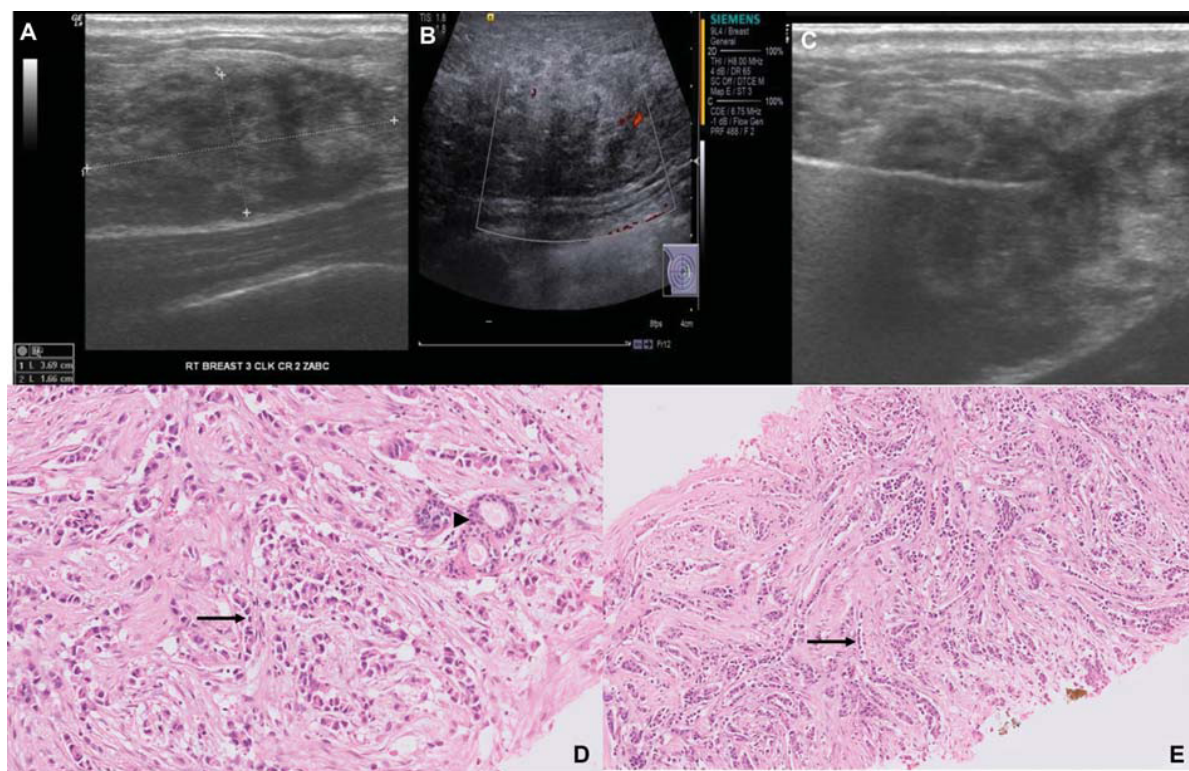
A 41-year-old lactating patient came with a history of a lump and pain in the right breast for 1 month which did not resolve despite a course of antibiotics. Her last child birth was 1 and half years back. Ultrasound shows an ill-defined oval hypoechoic lesion with minimal internal vascularity and an indistinct margin. Based on the history, a diagnosis of mastitis was made BIRADS III (A–C). The Biopsy was taken and the corresponding pathological image (D, E) an infiltrating malignant neoplasm composed of cells arranged in a typical Indian file pattern (arrow) with entrapped normal ductules (arrowhead). The invasive tumor cells have mild nuclear atypia with scant cytoplasm consistent with invasive lobular carcinoma, grade 2. The Biopsy was taken and the corresponding pathological image (D, E) an infiltrating malignant neoplasm composed of cells arranged in a typical Indian file pattern (arrow) with entrapped normal ductules (arrowhead). The invasive tumor cells have mild nuclear atypia with scant cytoplasm consistent with invasive lobular carcinoma, grade 2. This is an example of an interpretative error of the Imaging findings. The Pregnancy associated breast cancer must always be kept in mind and it would have been appropriate to categorize this lesion as BIRADS IVa.
